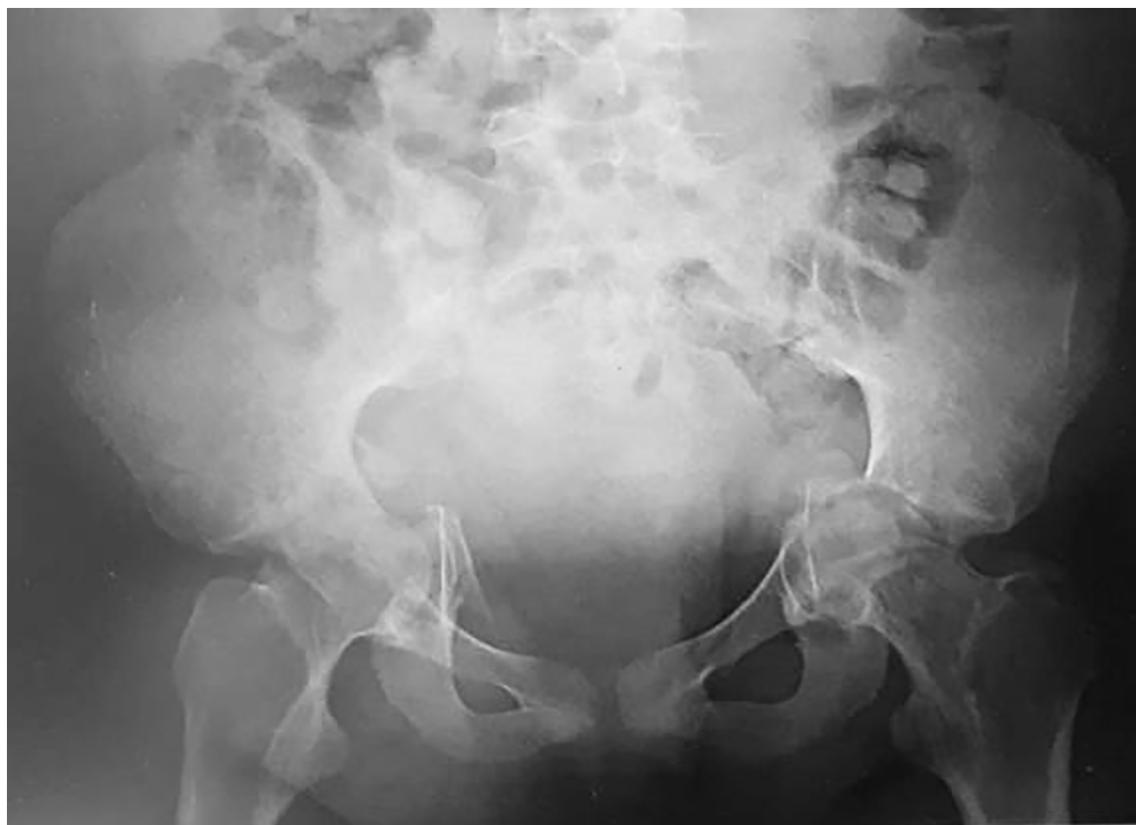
The first X-ray show bilateral multifragmentary fracture of the acetabulum and protrusion of the femoral heads in the pelvis.
